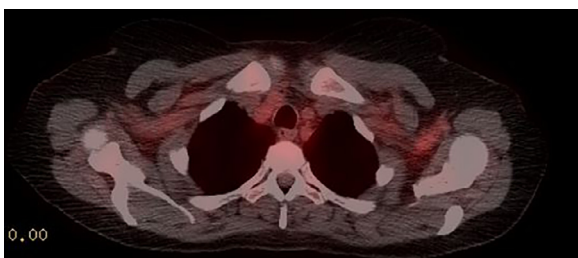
Axial section of a PET CT demonstrating FDG-avidity in the right and left subclavian arteries and carotid arteries bilaterally.
